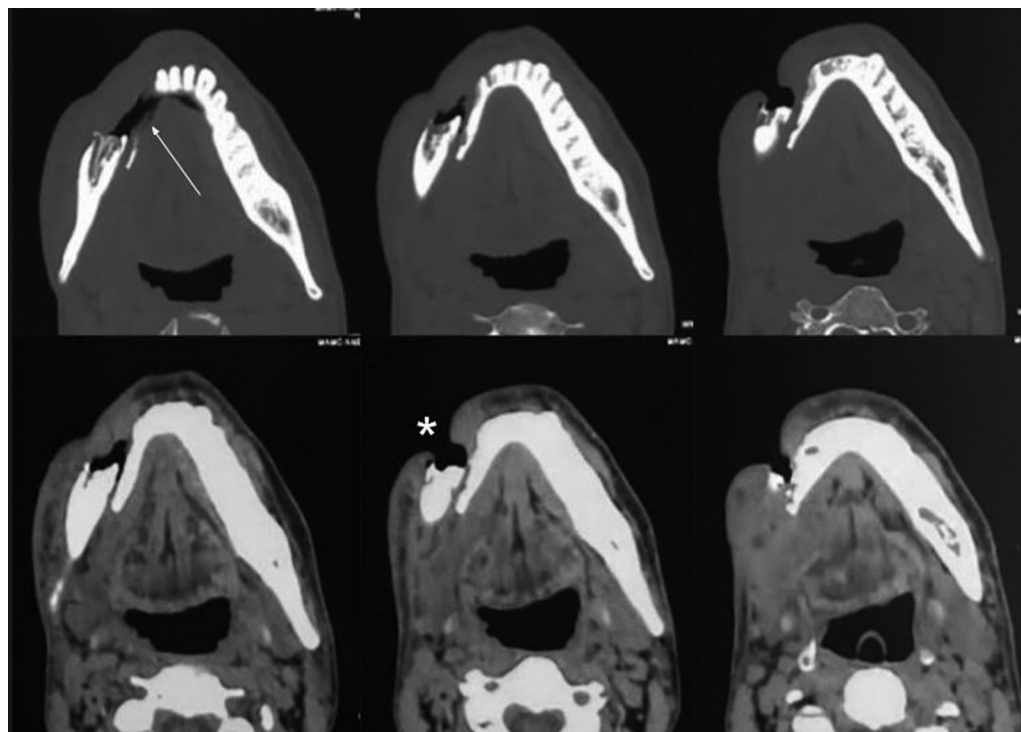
Mucormycosis mandible with pathological fracture. Computed tomography (CT) shows a bony defect in the right hemimandible (white arrow) with surrounding lytic sclerotic areas and fistulous communication from the skin surface to the right lower alveolus of the mandible (asterisk). Soft tissue thickening and fat stranding are seen in the right buccal space and on the right side of the face.
